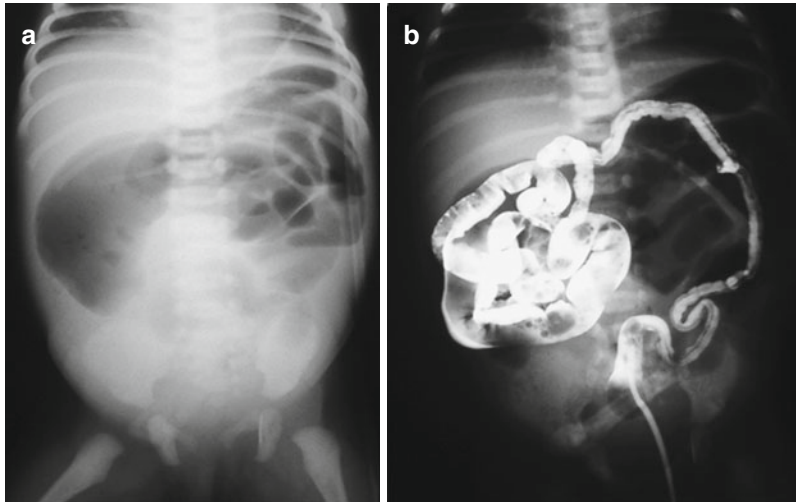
(a, b) Plain film (a) and enema (b) in infant with meconium ileus; note at the plain film the proximal distended loops with no air in the lower abdomen. The enema shows a condition on disuse microcolon within typical filling defect
